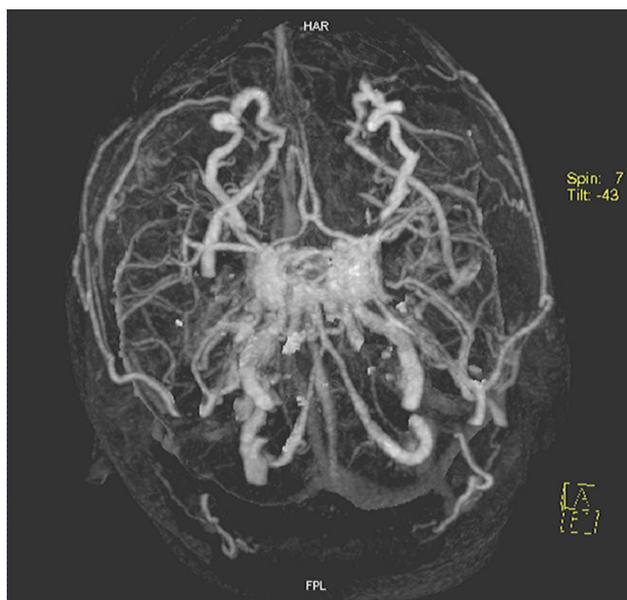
Computed tomography (CT) angiogram demonstrating bilateral carotid-cavernous sinus fistulae with arterialisation of the ophthalmic veins
